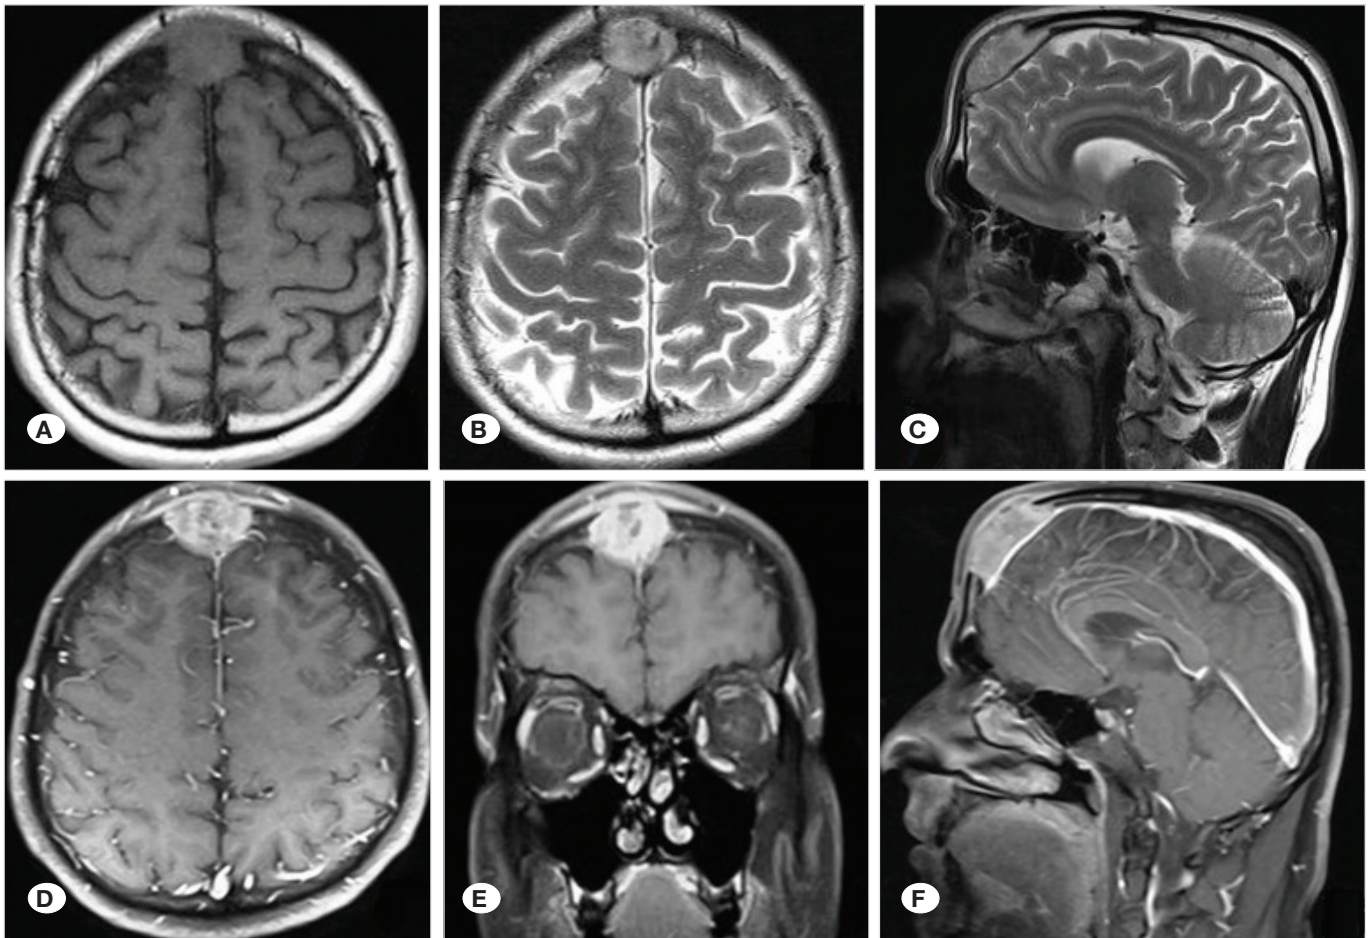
Preoperative MRI sequences. A) T1W axial, B) T2W axial, C) T2W sagittal, D) T1W axial+with contrast (Dural tail like appearance extending on both sides mimicking meningioma), E) T1W coronal+with contrast, F) T1W sagittal+with contrast.
